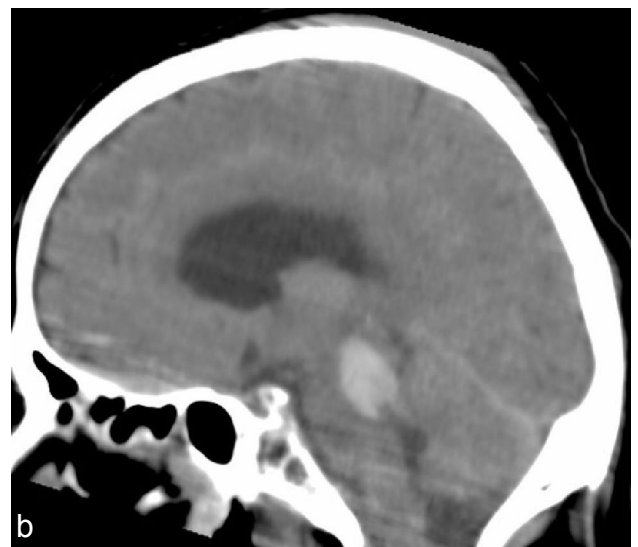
CT scan Axial & Sagittal Brain Image: A contusion hematoma is seen in pons on left side with extension into midbrain superiorly and left cerebellar peduncle inferiorly. There is subarachnoid hemorrhage with blood in cortical sulci, tentorium and interhemispheric fissure
